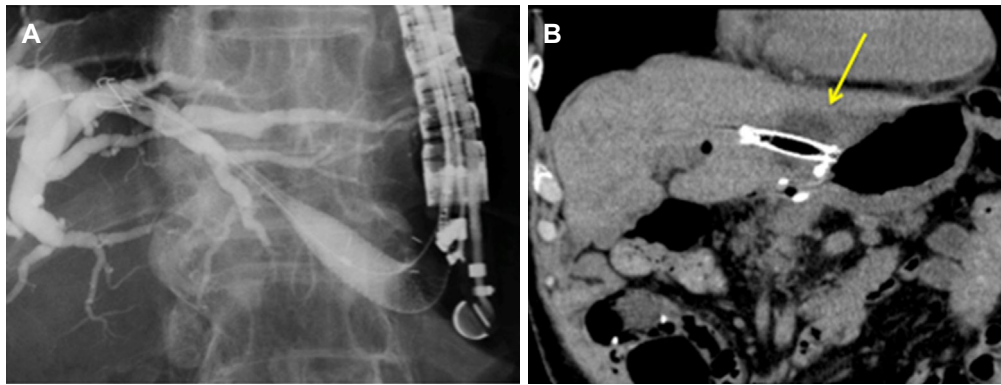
(A) Endoscopic ultrasound-guided hepaticogastrostomy using covered metal stent; (B) infected biloma is seen around endoscopic ultrasound-guided hepaticojejunostomy stent (arrow)
